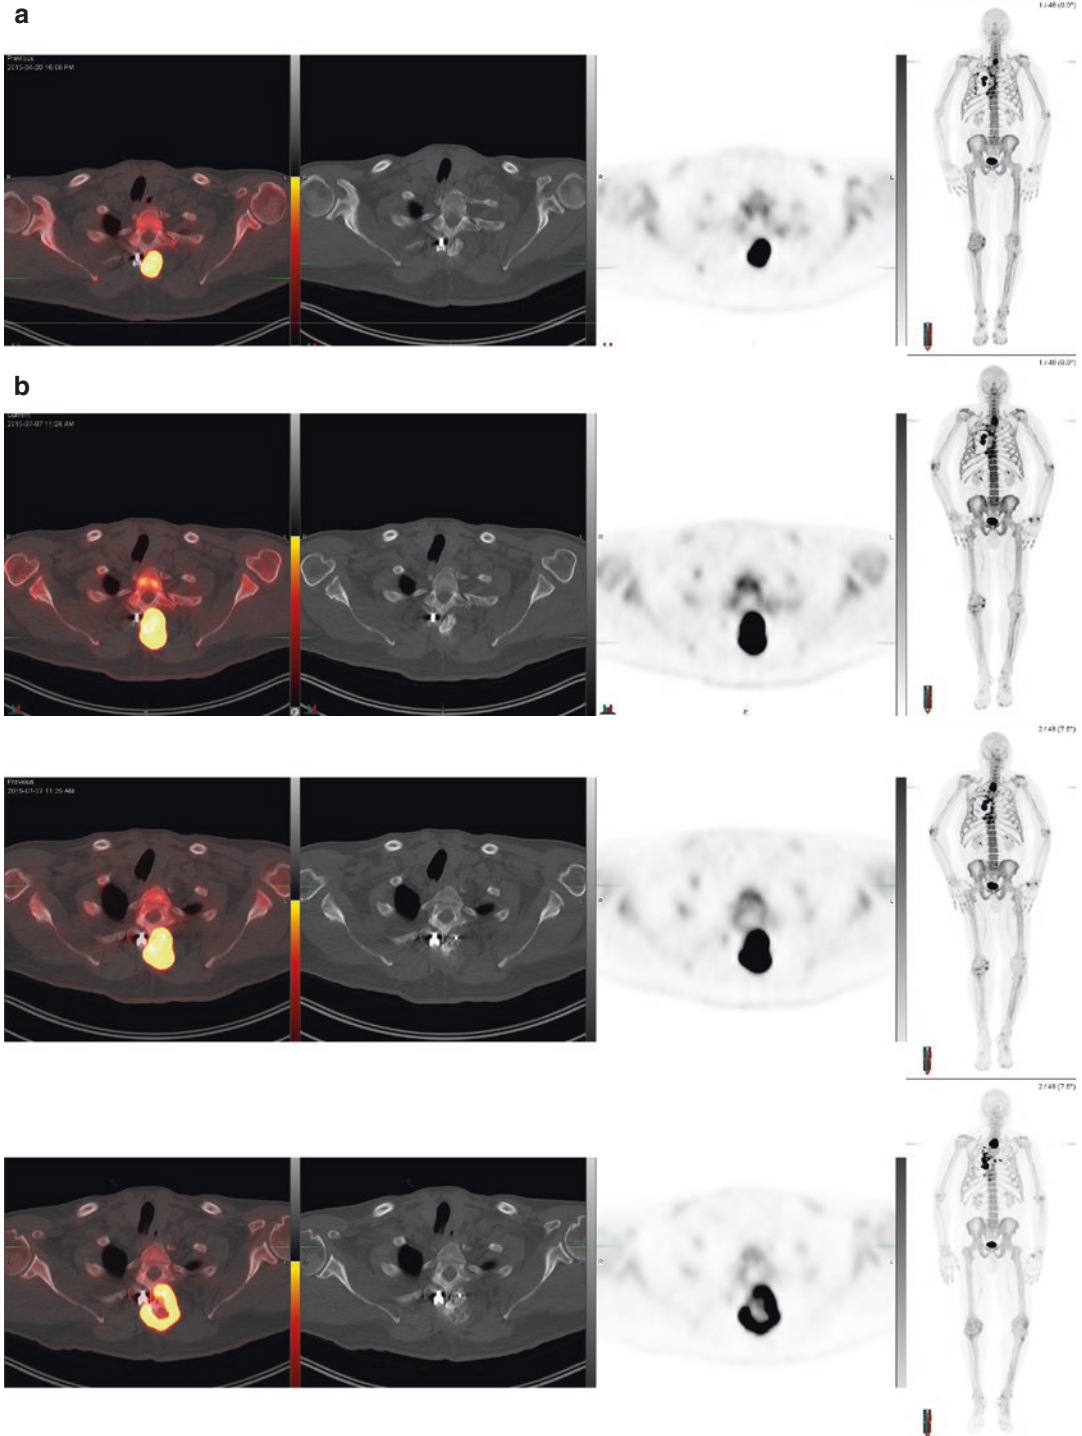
19-year-old male with osteosarcoma of the right fibula post resection, systemic therapy, RT to L1 and left sacrum. The upper row shows NaF PET/CT baseline prior
